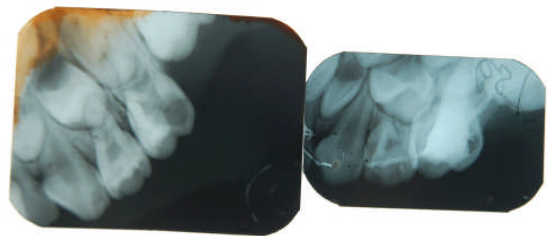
IOPA radiographs showing taurodontism of upper left second primary molar, pre and post pulpectomy
